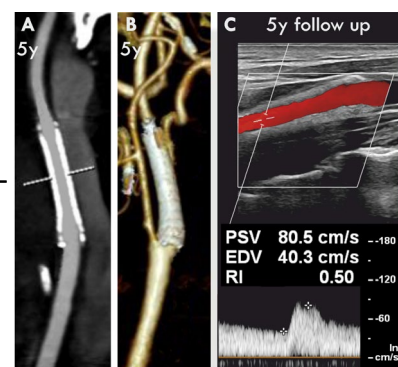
At 60 months – a fully maintained optimal treatment result, normal in-stent velocities, absence of any in-stent re-restenosis on CT angiography (A,B).
